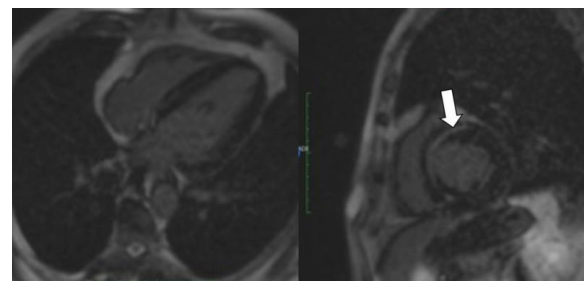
MRI images showing myocardial injury after first dose of COVID-19 vaccination in a 27-year-old woman. Delayed enhancement imaging was performed utilizing an SSFP sequence following the administration of Gd-based contrast agent. Four-chamber and short axis views demonstrate delayed enhancement of the septum (arrow).
